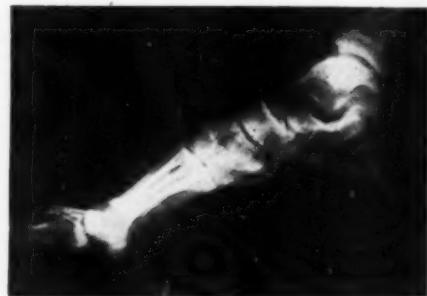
Fracture of sesamum peroneum: roentgenogram taken Oct. 17, 1938.
